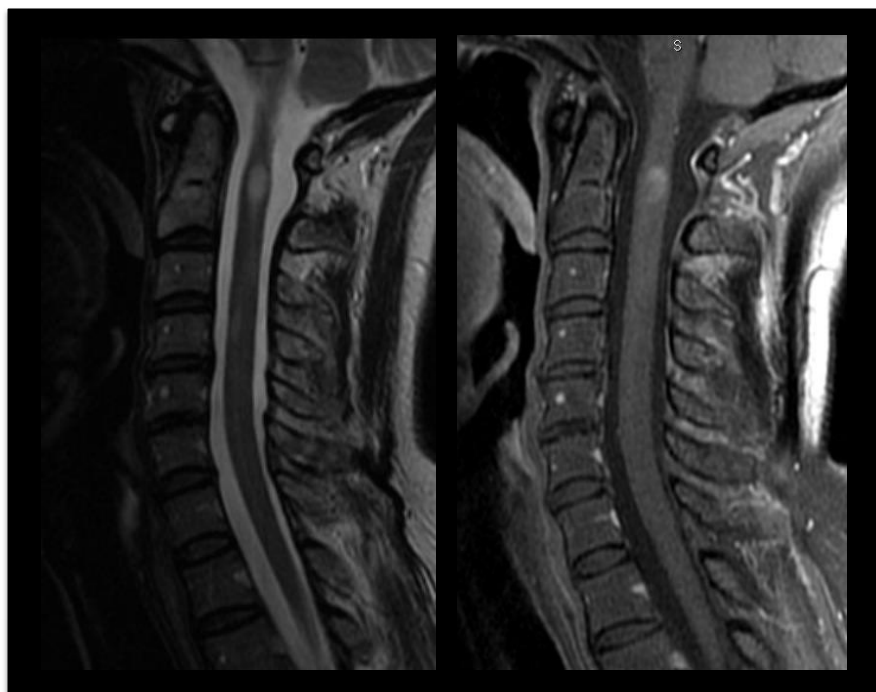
Active cervical cord lesion in MS on sagittal MRI. Lesion is visible as T2 hyperintensity (left) and enhances after Gadolinium injection on T1-weighted scan (right). MS lesions typically extend over <2 vertebral segments.
